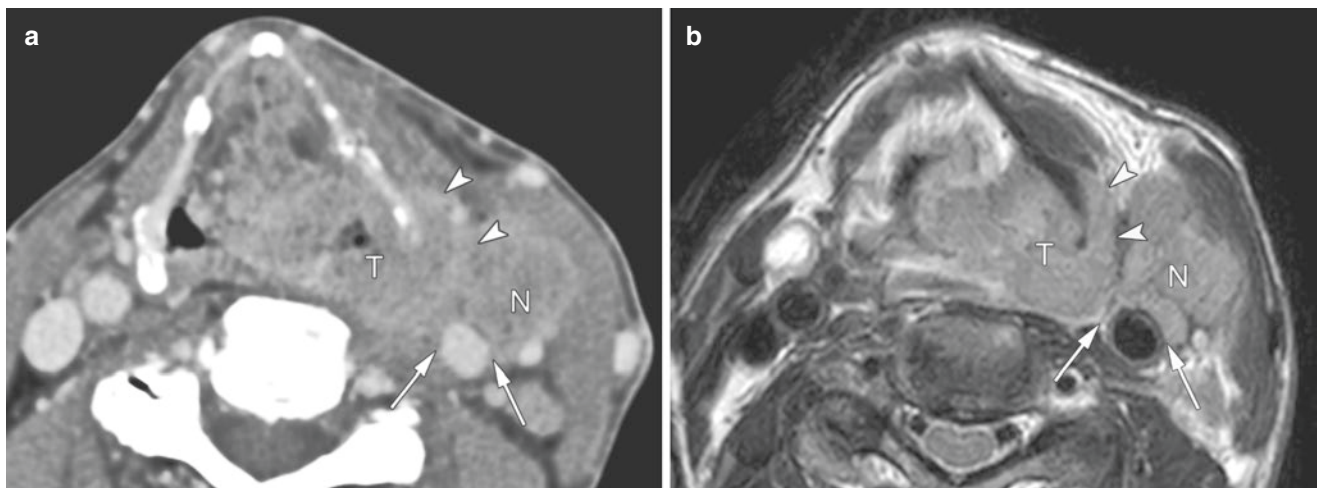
Wraparound spread with advanced pyriform sinus carcinoma with ENE node metastasis. Axial contrast-enhanced CT (a) and T2-weighted images (b) demonstrate a large tumor mass (T) arising from the left pyriform sinus, spreading into the lateral extralaryngeal soft tissue via the attachment of the inferior pharyngeal constrictor
